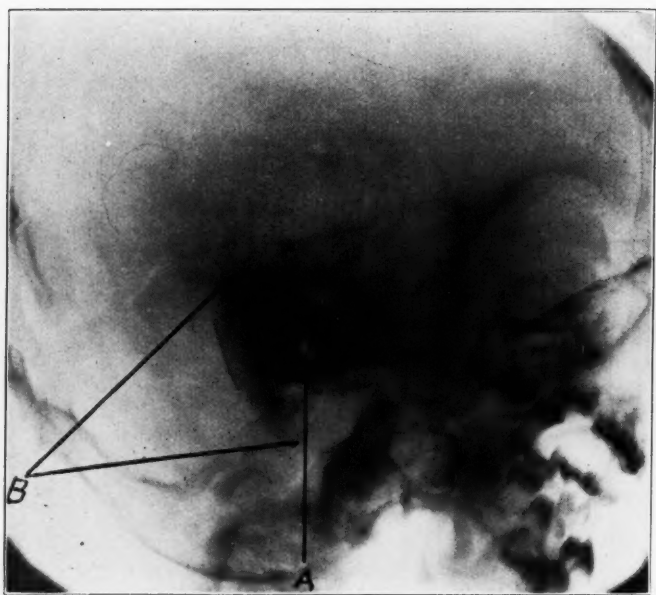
Roentgenogram of 7 months mastoid from infant with violent dehydrating enteritis. This cavity contained swollen edematous mucosa and purulent material. Infecting organism, hemolytic streptococci. A, auditory canal; B, outline of mastoid space showing generalized increased density.
